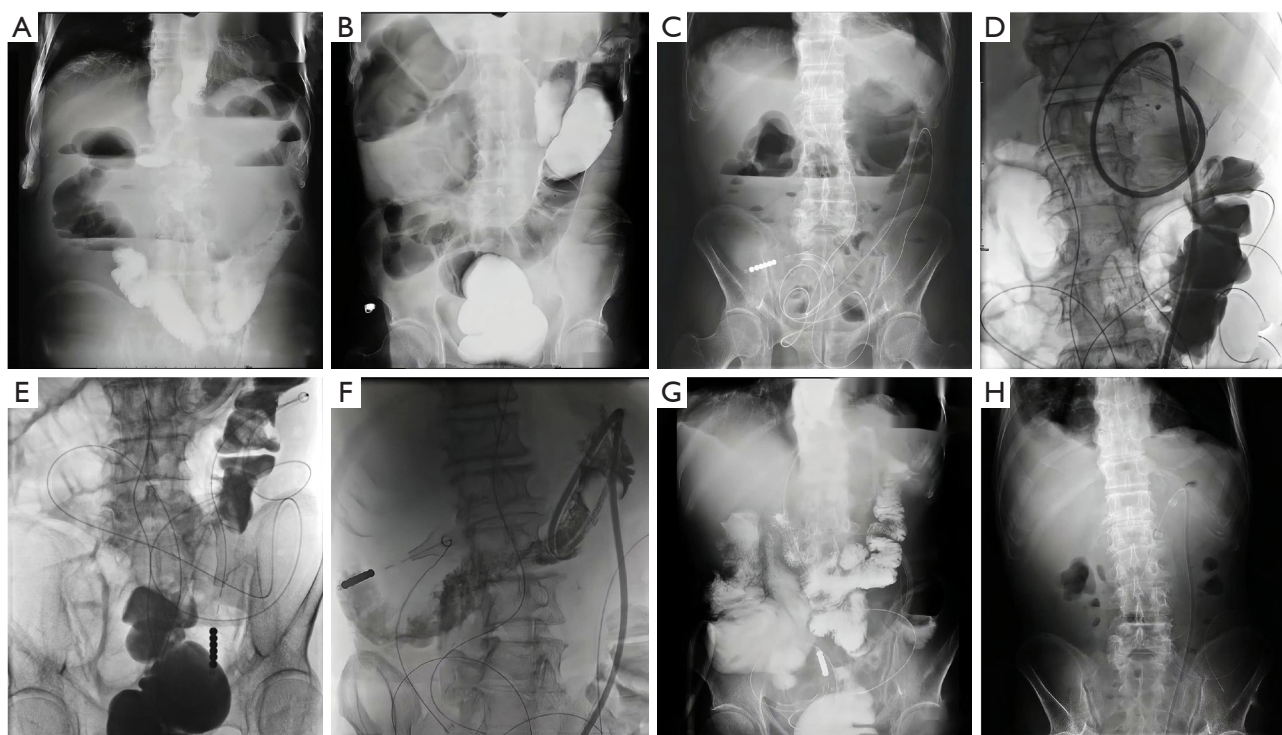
Treatment course of 2 ileus catheters in patient 3. (A) Multiple air-fluid level shadows arranged in steps on standing abdominal plain film 10 days before surgery; (B) significant colonic dilatation on lower gastrointestinal radiography 6 days before surgery; (C) air-fluid level shadows were reduced, but the colon was still significantly dilated on standing abdominal plain film 2 days after transnasal ileus catheter placement; (D) transanal ileus catheter placement; (E) radiography after placement of intestinal obstruction catheter confirmed the drainage effect; (F) showed that the colonic dilatation was basically relieved 5 days after operation; (G) air-fluid level shadows were eliminated by gastrointestinal radiography 6 days after surgery; (H) complete remission of intestinal obstruction on standing abdominal plain film 18 days after surgery.
